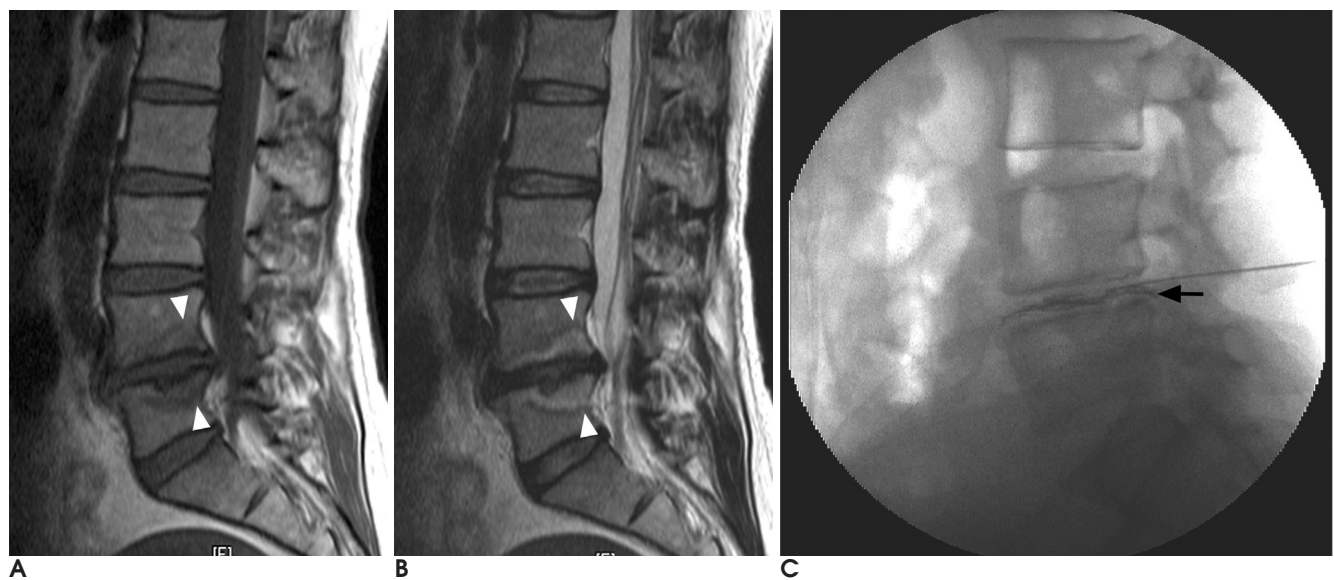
MR images of the lumbar spine in a 45-year-old woman demonstrate the criteria used to identify moderate endplate abnormalities.
